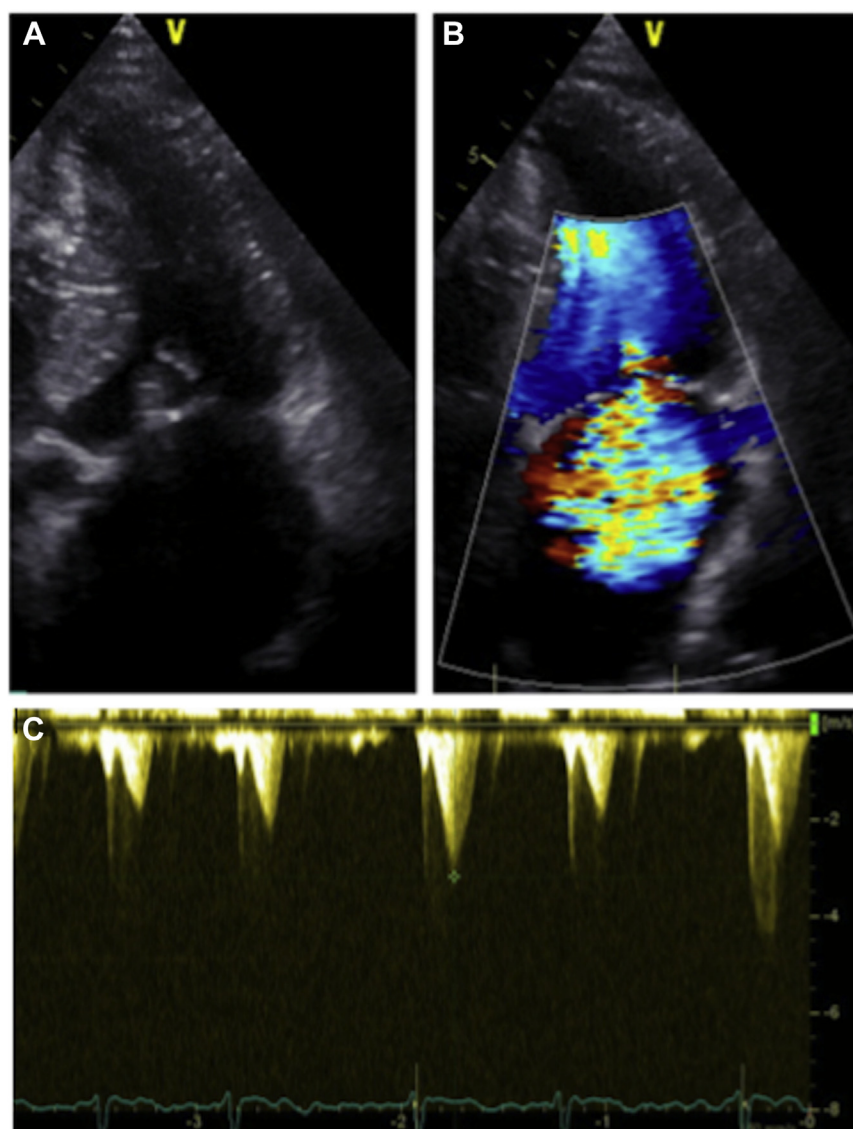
Transthoracic echocardiography showing a dilated left atrium associated with a systolic anterior motion of the mitral valve apparatus (A) and a severe central mitral regurgitation (B). Left-ventricular outflow tract obstruction driven by the systolic anterior motion (40 mm Hg) (C).
